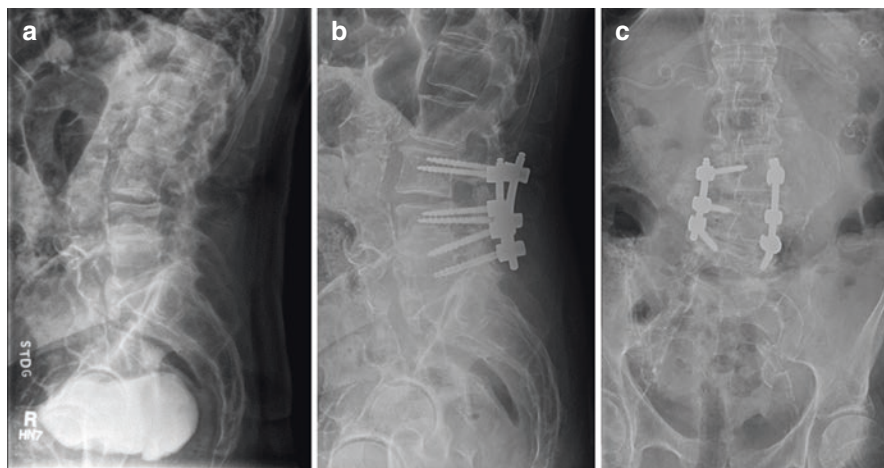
A 69-year-old male patient with a past medical history of chronic back pain, presenting for general weakness in his limbs. Preoperative X-ray (a) shows advanced degenerative arthritis in the lower lumbar spine with multilevel degenerative disk disease with low-grade spondylolisthesis. The patient underwent posterior decompression and fusion of L3-L5. Postoperative lateral (b) and AP (c) X-rays show instrumentation and posterior fusion of L3-L5
